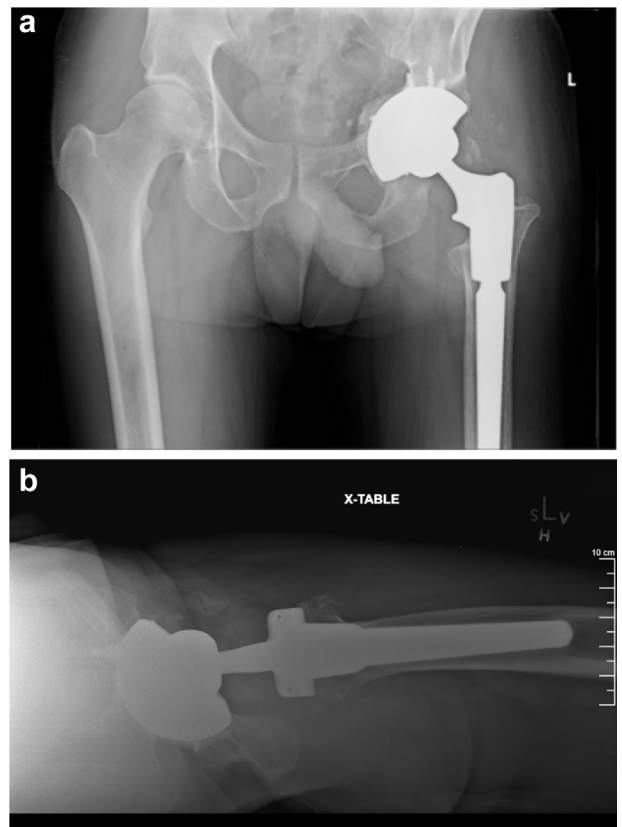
Postoperative AP (a) and direct lateral (b) radiographs demonstrate a well-fixed, well-positioned acetabular shell and modular femoral stem.
